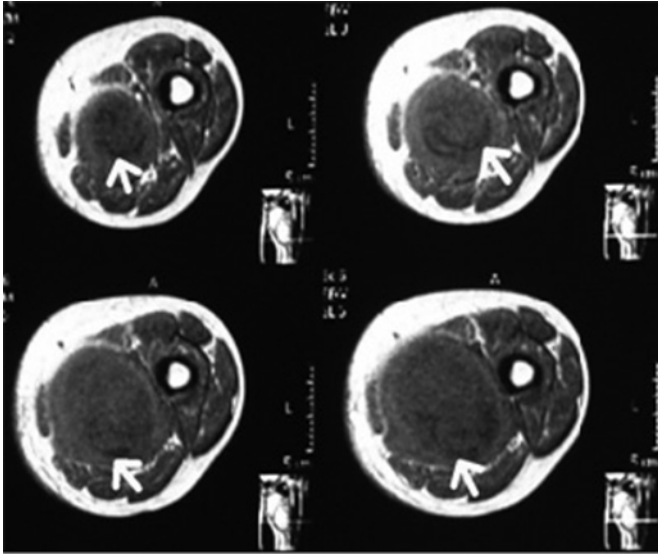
T1-weighted spin-echo axial MRI demonstrating low signal collapsed membranes “Water-Lily” sign (white arrows).
